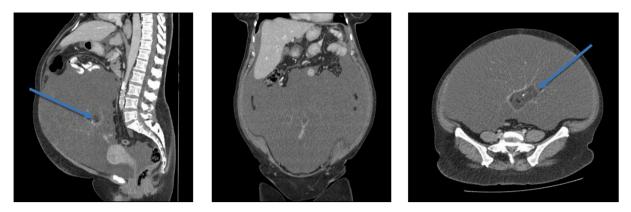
Case 2: CT abdomen and pelvis showing 30 cm complex cystic lesion with fat centre and large volume ascites but no peritoneal or omental disease. Arrows indicating fat foci within the mass.
